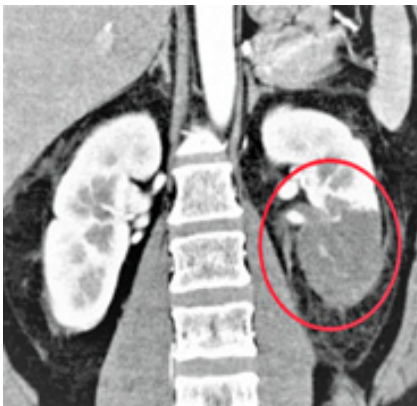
CTA Abdomen, Red circle shows the occlusion of the supplying small inferior segmental artery and minimal atherosclerosis causing the infarction of the anterior two-thirds of the lower pole of the left kidney.
